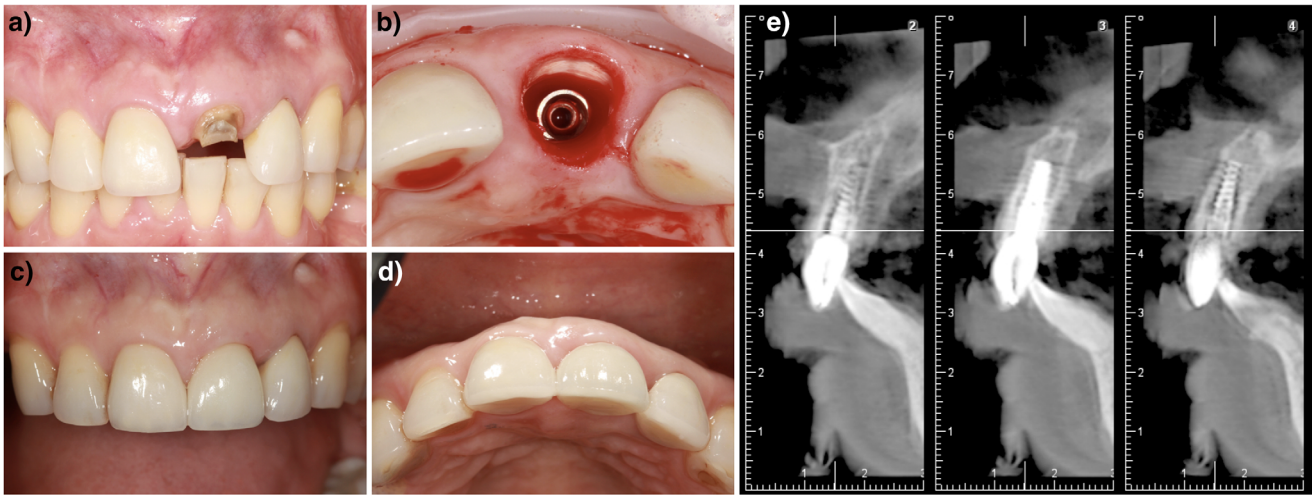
a Frontal image. Vertical root fracture of the maxillary left central incisor. 3b Immediate implant position. 3c Frontal view of the crown 3 years after the prosthetic insertion. 3d Occlusal view of the crown 3 years after the prosthetic insertion. 3e A CBCT image at 3 years postoperative.
